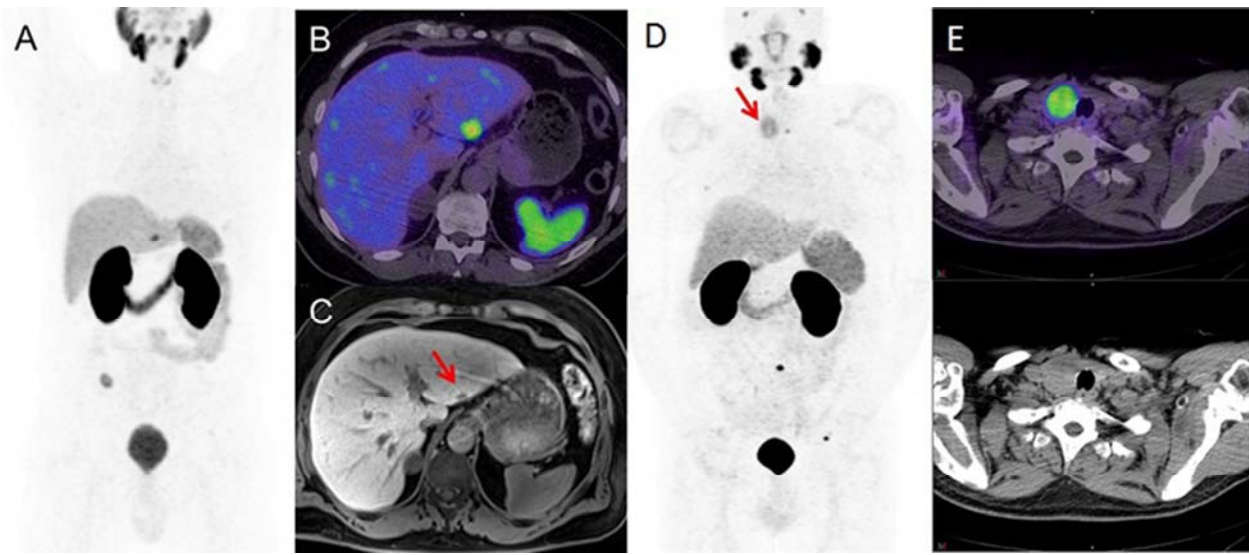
(A): MIP, (B): PET/CT, C: delayed contrast MRI. Small liver lesion (SUVmax 15) with no abnormality seen on low dose CT. MRI demonstrated arterial phase enhancement matching blood pool consistent with a hemangioma. (D): MIP, (E): fused axial PET/CT and CT. A 40mm thyroid nodule (SUVmax 6.3). Ultrasound demonstrated predominantly solid, mainly hyperechoic lesion with low echoic rim and increased vascularity. Biopsy demonstrated benign hyperplastic nodule (Bethesda category 2).
